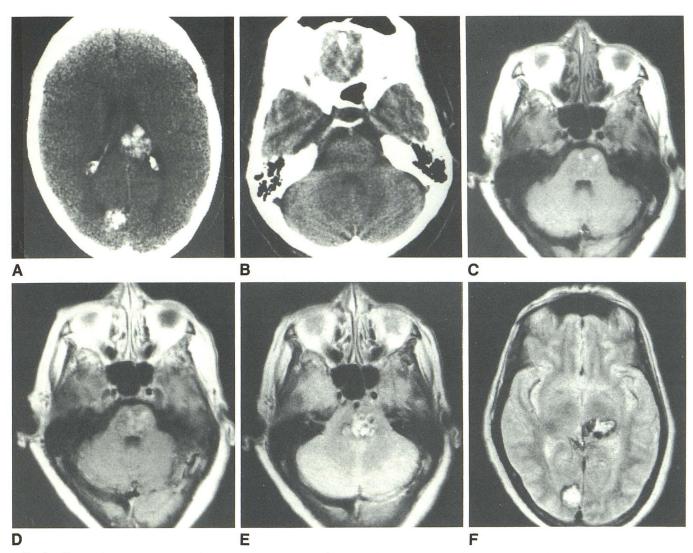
53-year-old woman with visual flashes, hearing loss. A, B, CT shows two partially calcified lesions; one in left thalamus, one in right occipital cortex. Brainstem appears normal. Angiography was negative. C, TR = 500, TE = 30 msec. MR shows third lesion in brainstem, missed with CT. High-intensity foci on T1- and T2-weighted sequences suggested subacute bleeding in lesion. Lack of brainstem signs or symptoms suggested occult arteriovenous
